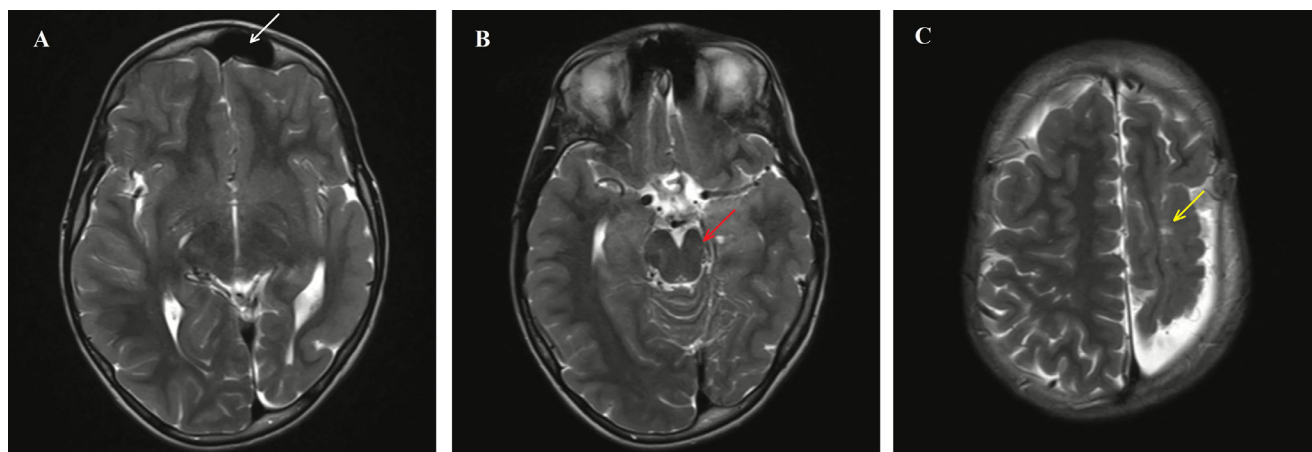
Axial T2-weighted MRI images: (A) Demonstrating hyperpneumatization of the frontal sinus on the left side (white arrow). (B) Demonstrating atrophy of the left side of the midbrain (red arrow). (C) Demonstrating abnormal signal in the left corona radiata owing to an underlying pathology (yellow arrow).
